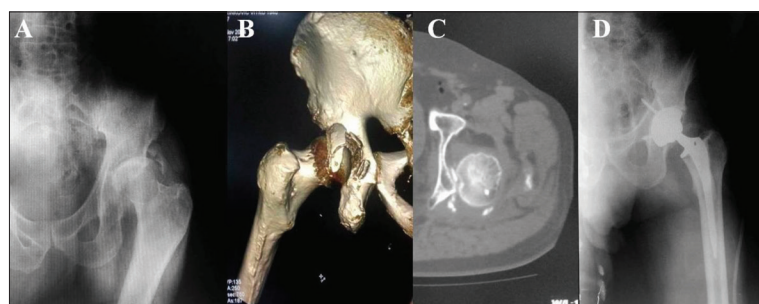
Primary total hip replacement after fresh posterior wall acetabular fracture with posterior hip dislocation in a 74-year-old patient; A: X-ray after the injury; B: 3D computed tomography (CT) view; C: sagittal CT view shows posterior hip dislocation with a fracture of the posterior wall of the acetabulum; D: X-ray after primary total hip replacement
